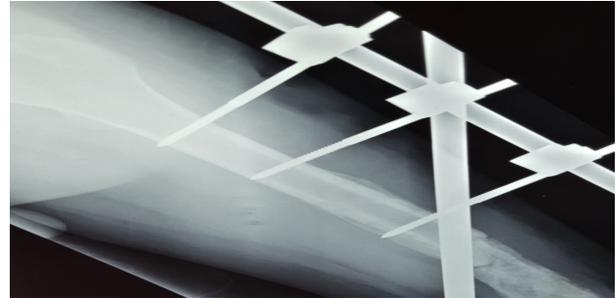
X-ray left femur 1 month after second stage surgery
